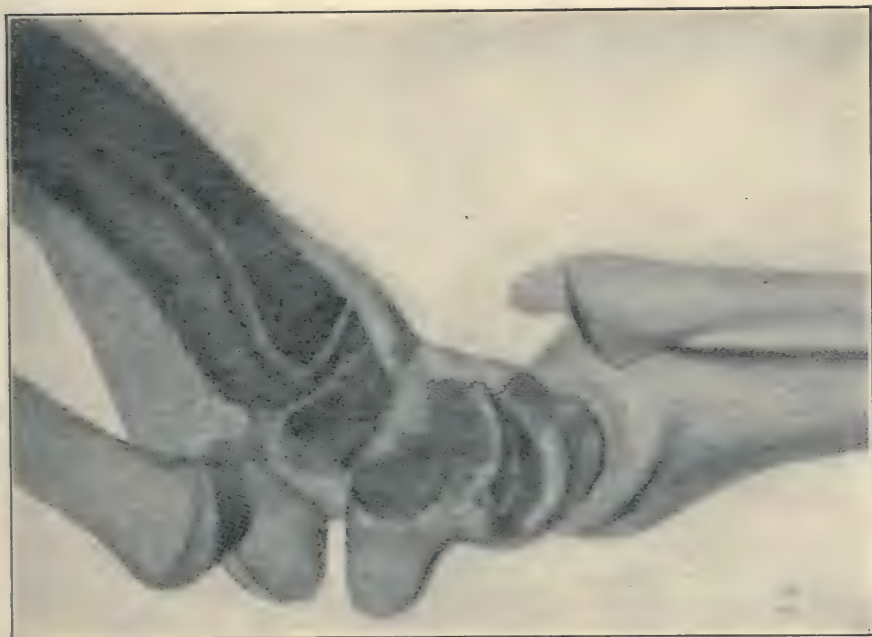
x-ray Photograph of the Left Wrist (the same case as that shown in Fig. 527). The points to be noted are: The os magnum is more voluminous than is normal, and it appears to have pushed upward the os semilunare, which in turn has pushed up the radius; the articular surface of the inferior extremity of the radius is no longer at right angles to the axis of this bone—a condition which predisposes to forward dislocation of the carpus; and the cubitus has lost its proper relations to both the carpus and the radius. (After Estor, in the *Revue de Chirurgie*, Paris, August 10th, 1907.)
